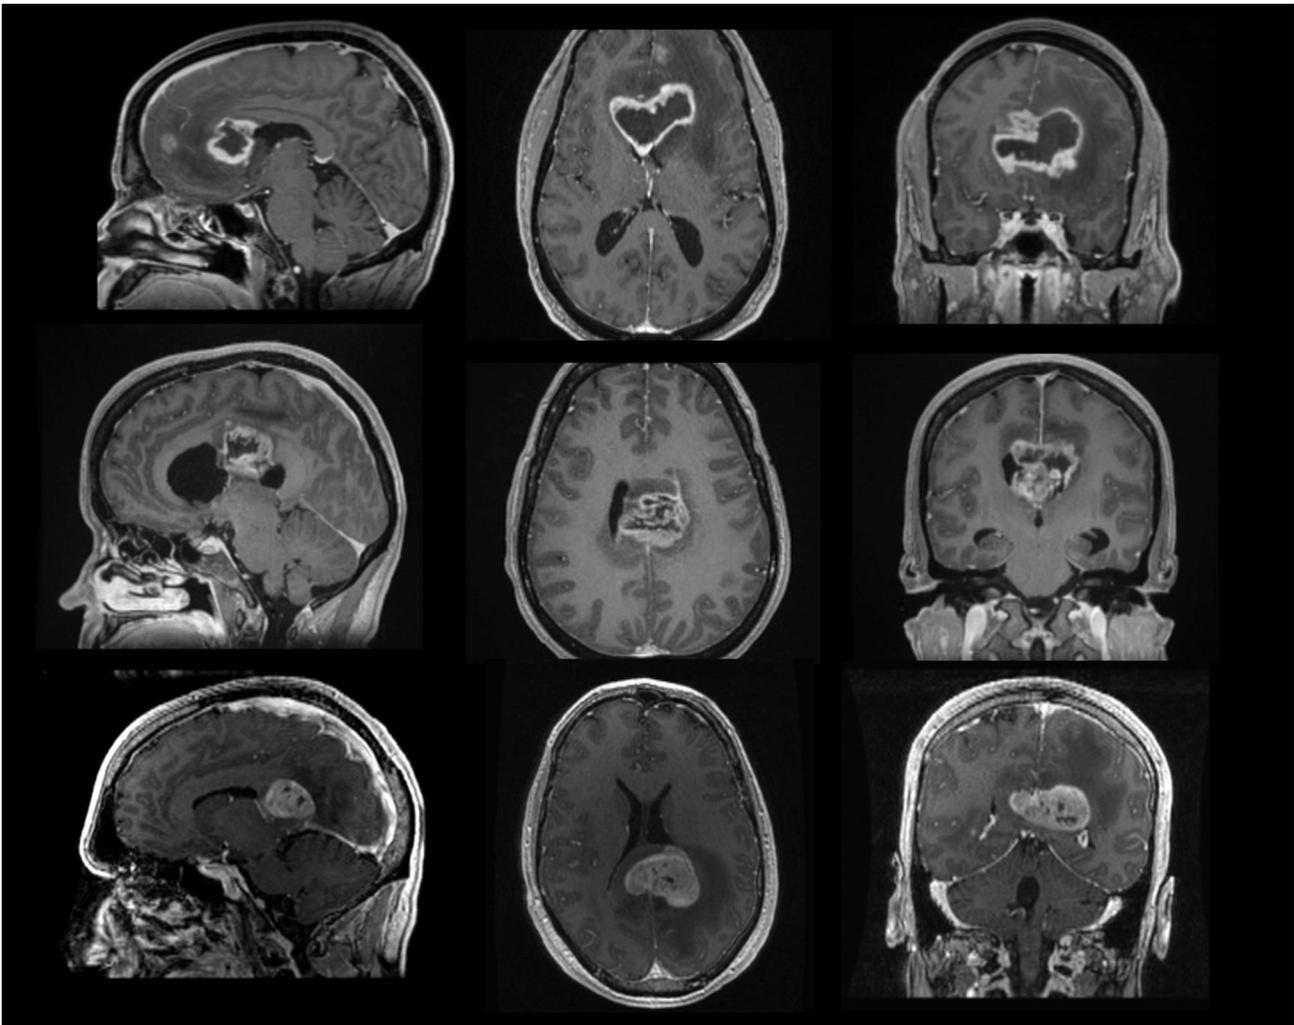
Butterfly glioma on MRI. Magnetic resonance T1 contrasted images on sagittal, axial and coronal planes of three different butterfly gliomas. The top series shows a tumor located in the genu, the middle series a tumor located in the body and the bottom series a tumor located in the splenium of the corpus callosum.
